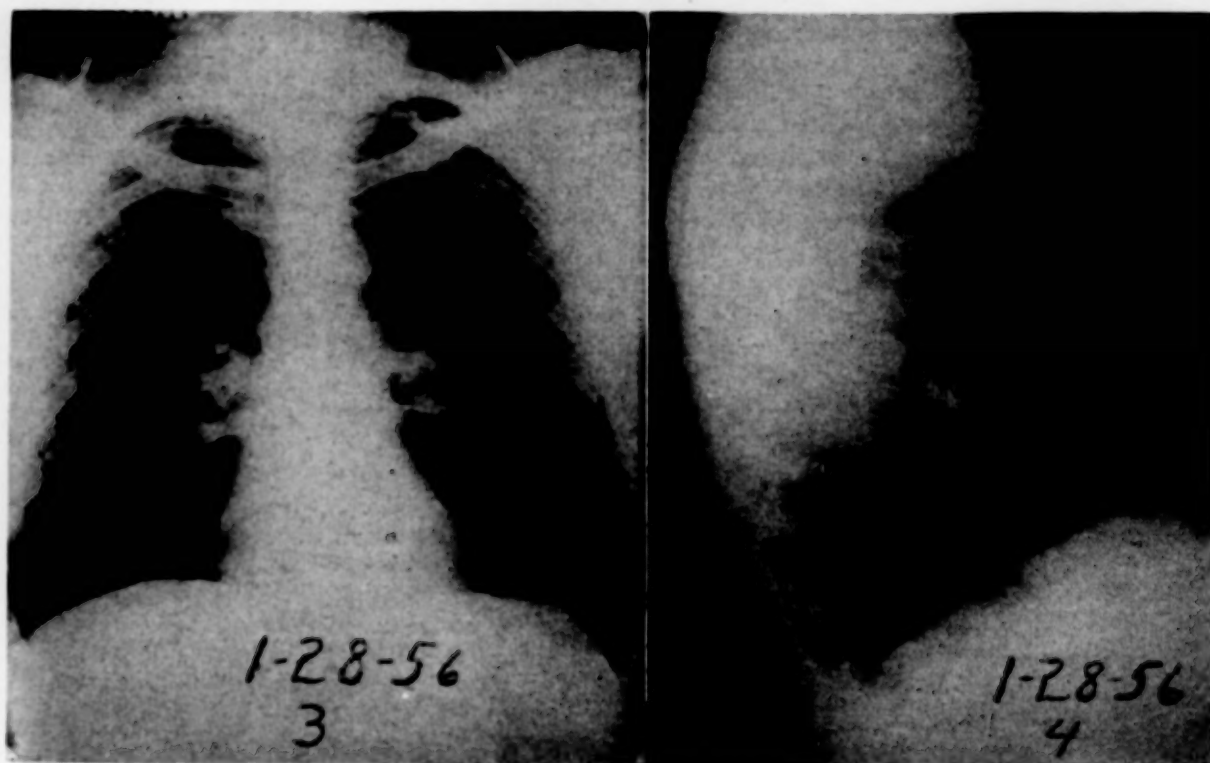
CASE II. Postoperative roentgenograms with re-expansion of right upper lobe.
